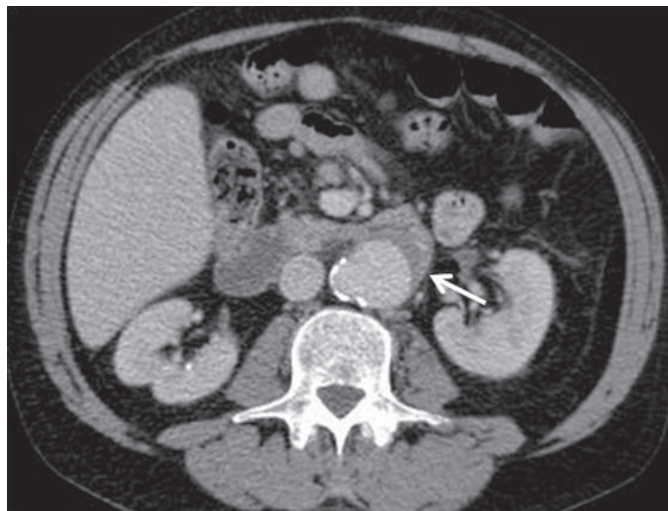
CT scan of abdomen with contrast IV portal phase and axial cut, where aortic wall calcifications and left lateral wall saccular aneurysm of infrarenal abdominal aorta of 48 mm maximum axial diameter are identified, which has grown since the previous study in 2016. The mural thrombus persists.
